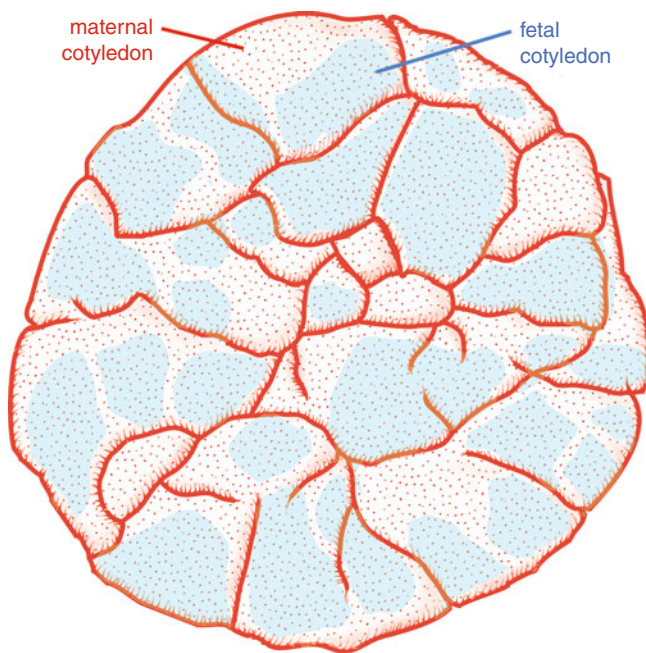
Basal view of the placenta, drawn in combination with a radiograph of the same placenta after injection of a radiopaque medium into the fetal vessels. The borderlines of the placental lobules (maternal cotyledons, *red stippled*) are marked by *red lines* corresponding to the grooves. The radiographic projections of 29 villous trees are represented by *blue stippled areas*. This combination demonstrates a fairly good harmony of villous trees and maternal lobes. One to three villous trees (fetal cotyledons) are projected on one lobe (maternal cotyledon) (From Kaufmann and Scheffen (1992), with permission; based on photographs by Boyd and Hamilton (1970))
